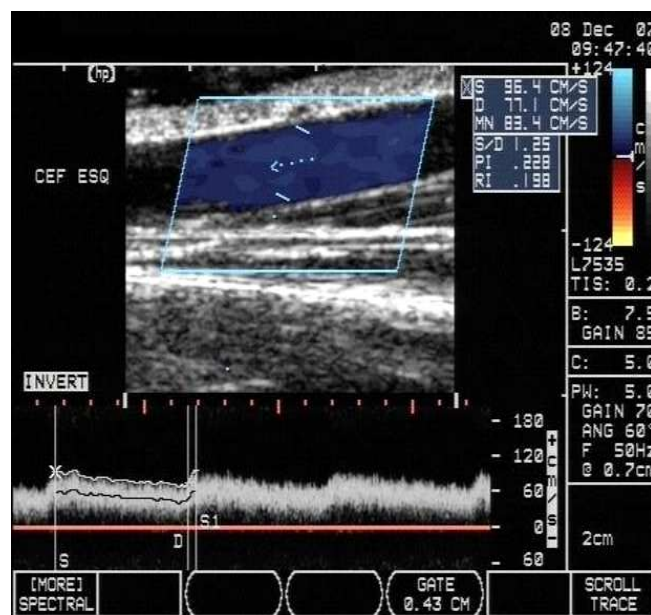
DUS of draining vein in the middle third of forearm, with the representation of image and spectral Doppler, and automatic measurement of average speed.
